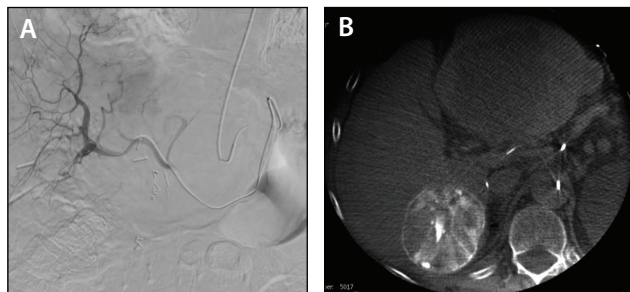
Embolization was performed with 40-μm Embosphere™ Microspheres until stasis. Confirmation postembolization angiography (A) and cone-beam CT were performed (B).
